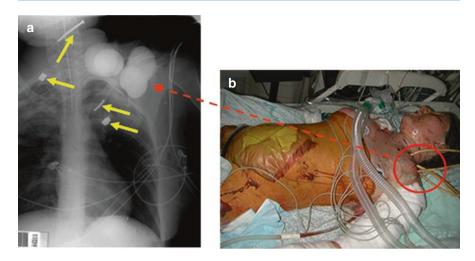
Chest X-ray of a 19-year-old woman injured from multiple shrapnel in a suicide bombing attack (a). She suffered from profuse bleeding from her left upper chest and shoulder area due to shrapnel penetrating wounds reaching from the shoulder area to the lung. Note foreign bodies (arrows) and presence of four inflated Foley catheters (b)
